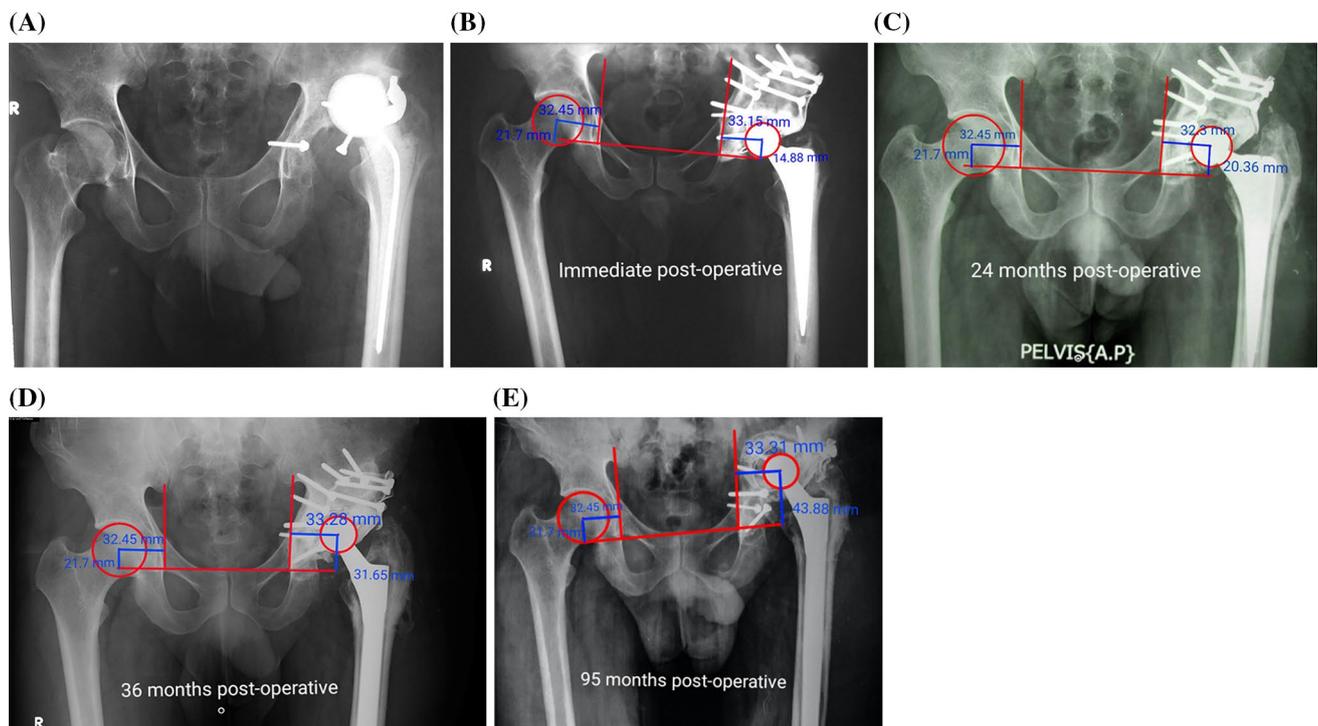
Male patient 36 years with type III AAOS defect. a Pre-operative AP pelvis radiographs, b immediate post-operative radiographs with restoration of the COR, c after 24-month follow-up, COR
